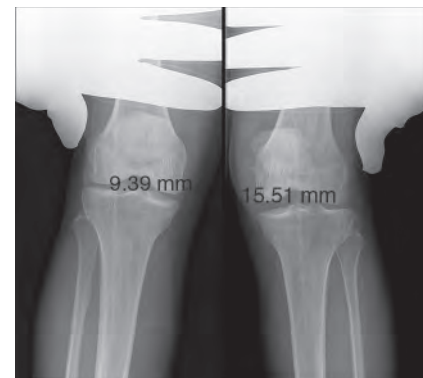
Valgus stress radiographs demonstrating a side-to-side difference of 6.2 mm of medial compartment gapping, which is indicative of a complete superficial medial collateral ligament injury.
